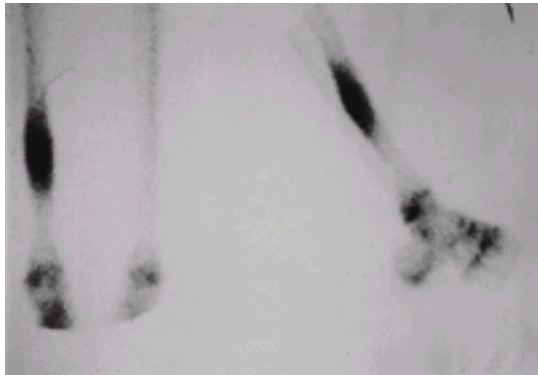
A skeletal scintigram using technetium-99m hydroxymethylenediphosphonate showing the characteristic high uptake in an osteoid osteoma, with its oval configuration and very 'hot' nidus.
